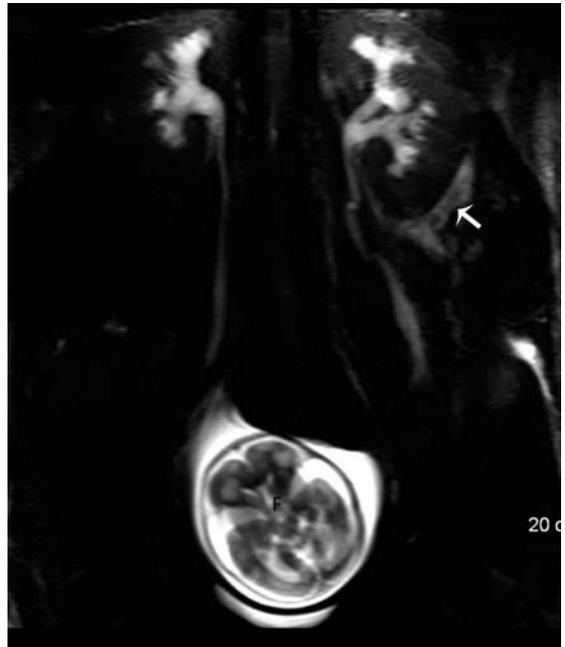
Physiologic hydronephrosis in a 33-year-old pregnant female with a triplet gestation. Coronal thick slab T2-weighted image demonstrates mild bilateral hydronephrosis and hydroureter to the level of the gravid uterus. Also note a small amount of left perinephric fluid (arrow) and one of the fetal heads (F). Perinephric fluid is more commonly associated with obstructive hydronephrosis, but can less commonly be seen with physiologic hydronephrosis.
